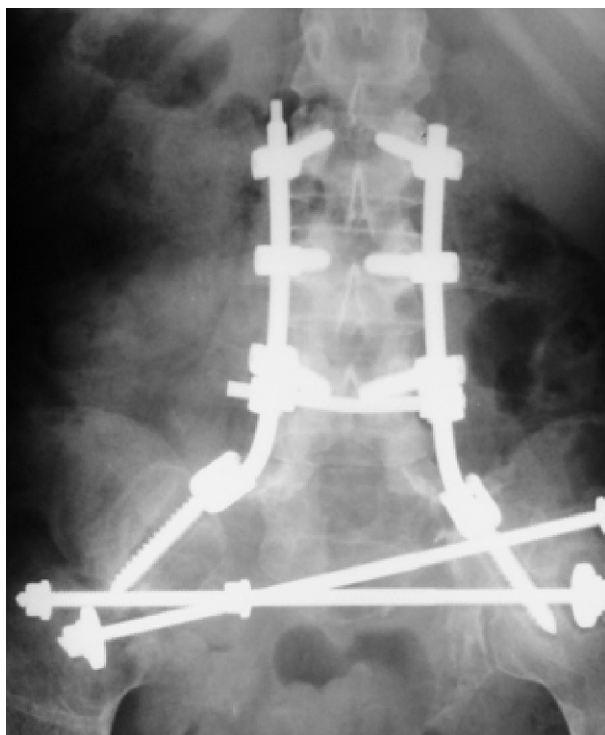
The post-operative X-ray lumbo-sacral spine (antero-posterior view) of case 2 showing two vertical rods with monoaxial pedicle screws transfixing lower lumbar levels (L2–L4) bilaterally along with two polyaxial screws in iliac bone on both sides. The cross links are also evident. This patient had a giant cell tumor (GCT) of the sacrum.
